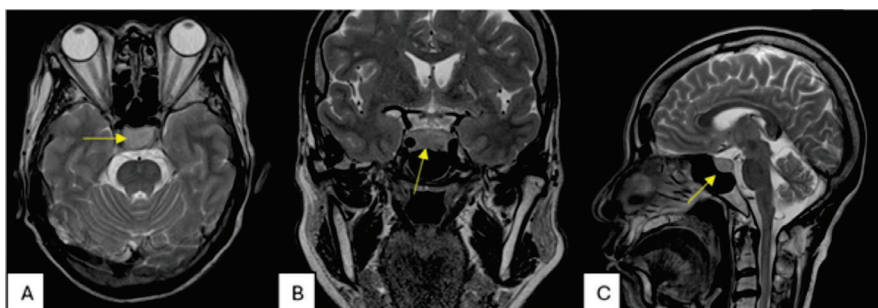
Brain MRI demonstrating an enlarged pituitary adenoma (yellow arrow) on (A) axial, (B) coronal, and (C) sagittal views.
